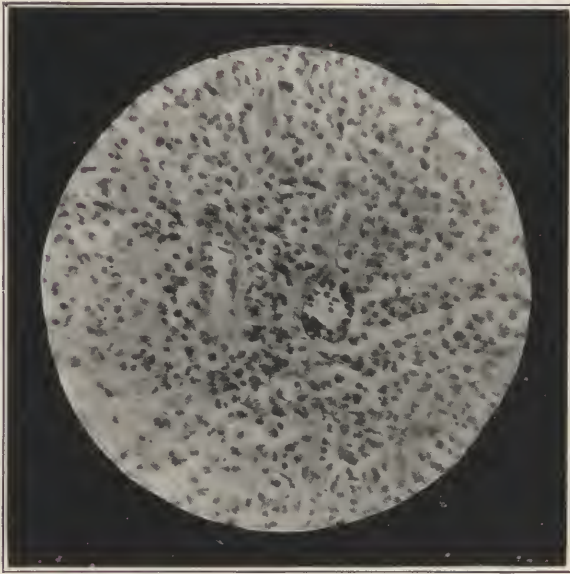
Chronic type of periapical inflammation. Preponderance of small round cells. Capillary blood vessels are seen, establishing a connection between the focus of infection and the general circulation.
